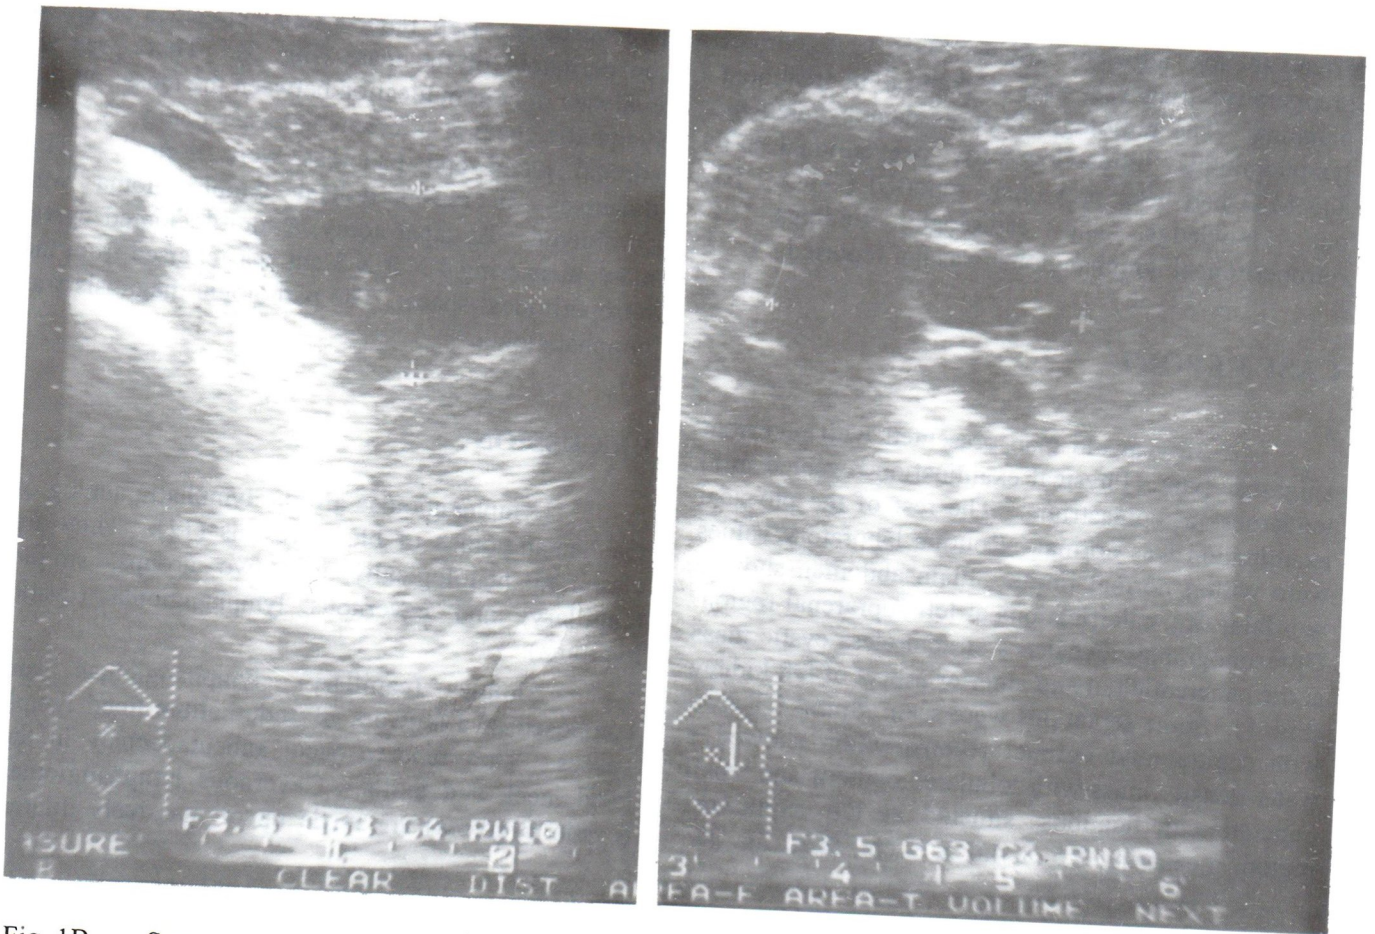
Sonogram in transverse plane (left) and parasagittal plane (right) showed multiloculated cysts with elongated shape.
